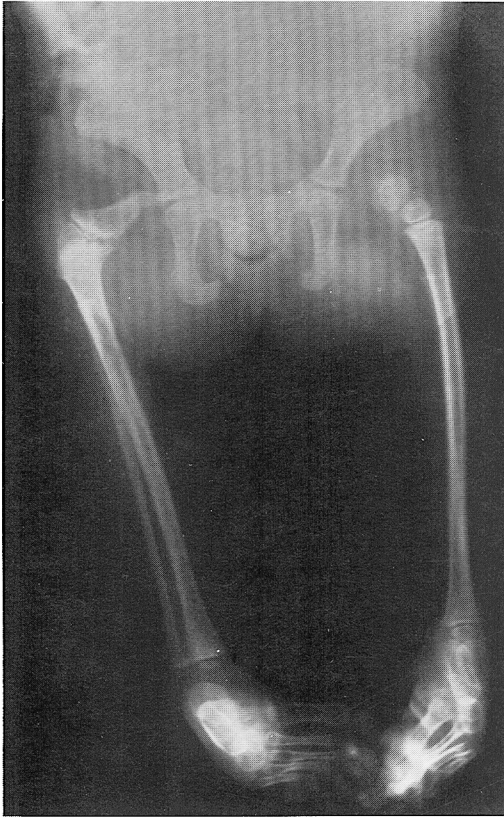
Radiograph of pelvis showing severely hypoplastic femurs, absent patellas and malformed feet bilaterally. Note normal orientation of tibia and fibula.
